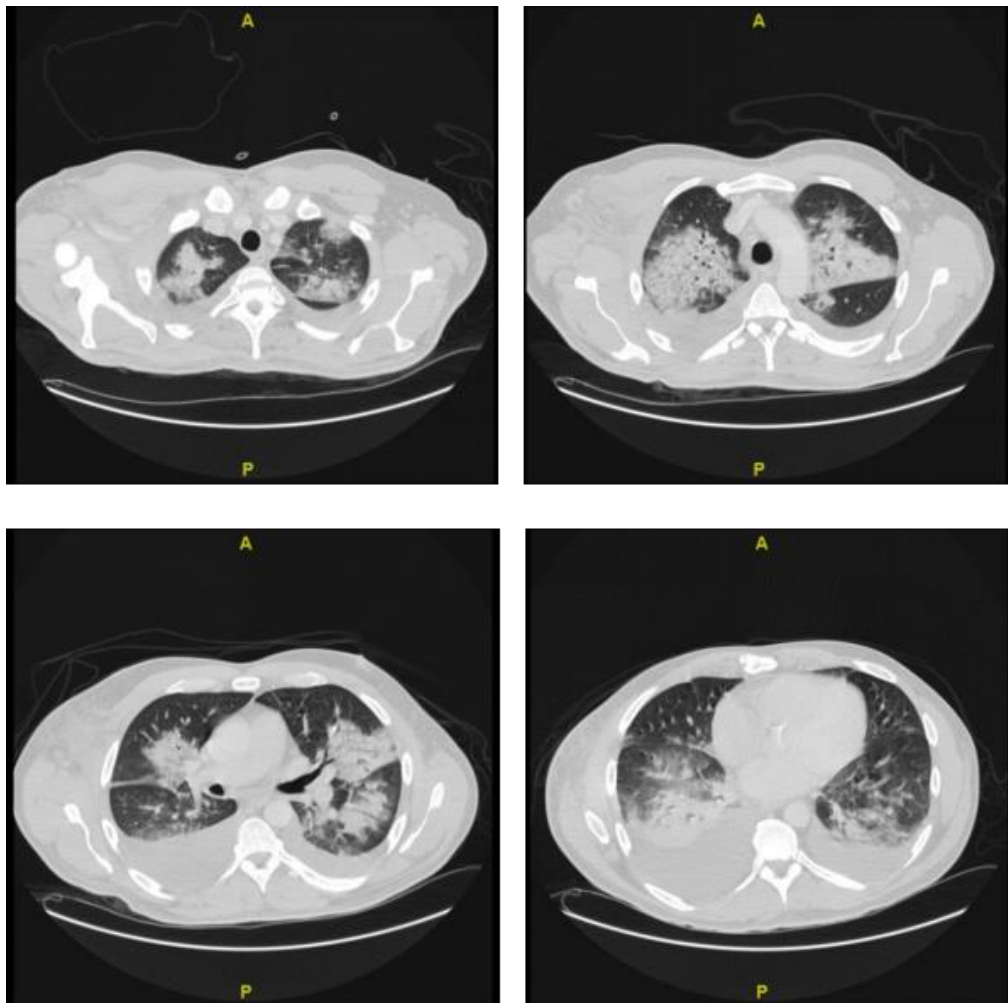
CT thorax on Day 6 suggestive of Acute Respiratory Distress Syndrome
